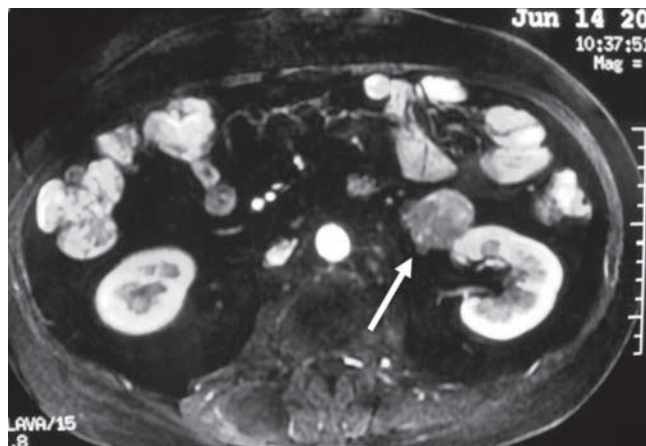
Abdomen MRI scan detecting a 3.0×3.5×5.3cm tumor in the anterior of left renal hilum and left renal vein, with abundant fatty component and plentiful vascular supply.
